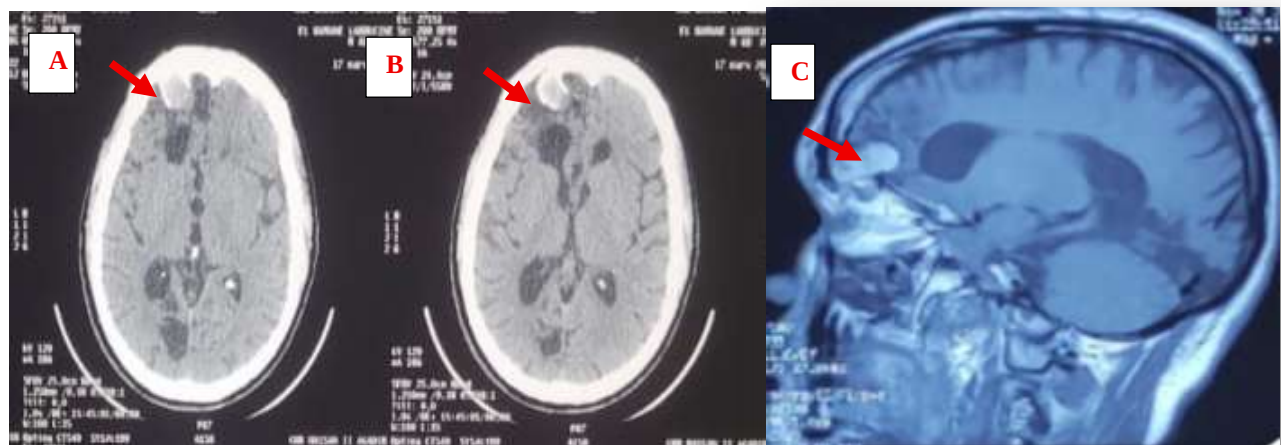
A, B: axial CT scan of our patient shows frontal mucocele with invasion of the right frontal lobe. C: Sagittal MRI scan of our patient, T1 weighted images sagittal sections showing: filling of the right frontal sinus with orbital and intracranial invasion by the mucocele.
